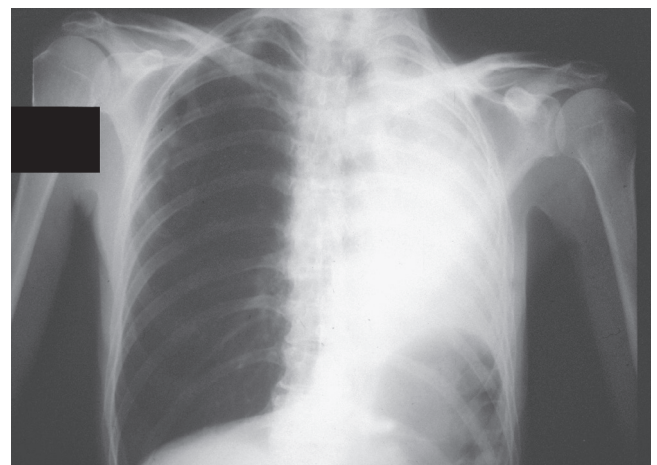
■ Radiographic picture of lung cancer obstructing the left mainstem bronchus before photodynamic therapy.
